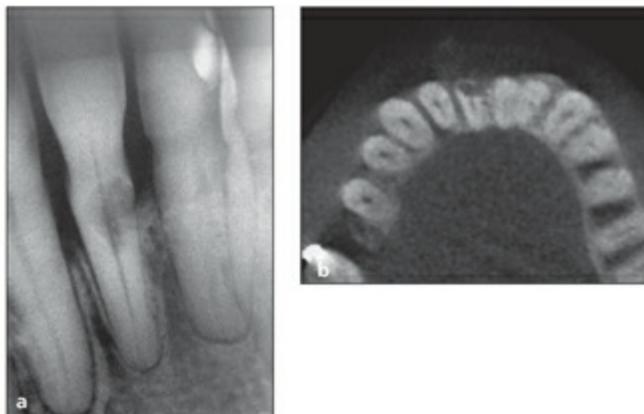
(a) Periapical view of the mandibular right central incisor showing subepithelial external resorption. (b) Axial cut from a volumetric reconstruction shows the location, extent, and proximity of external resorption to the root canal. (Reprinted from Cohenca et al¹³⁵ with permission.)
